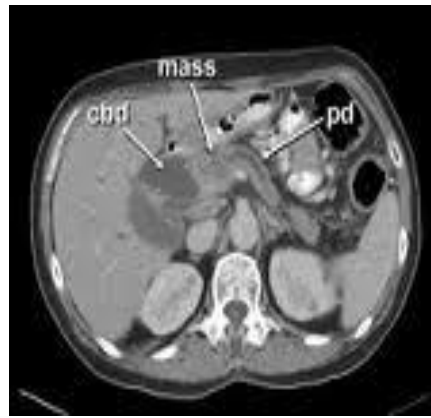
Mass in head of pancreas on CT scan.
